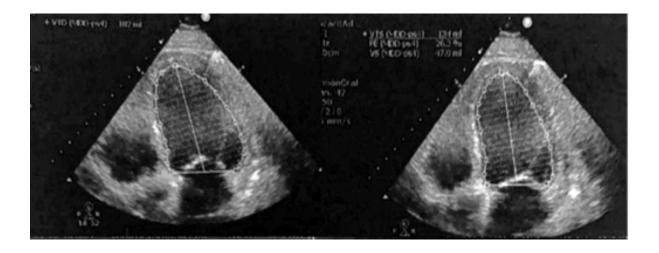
Baseline echocardiogram. Shows severely depressed systolic function.
